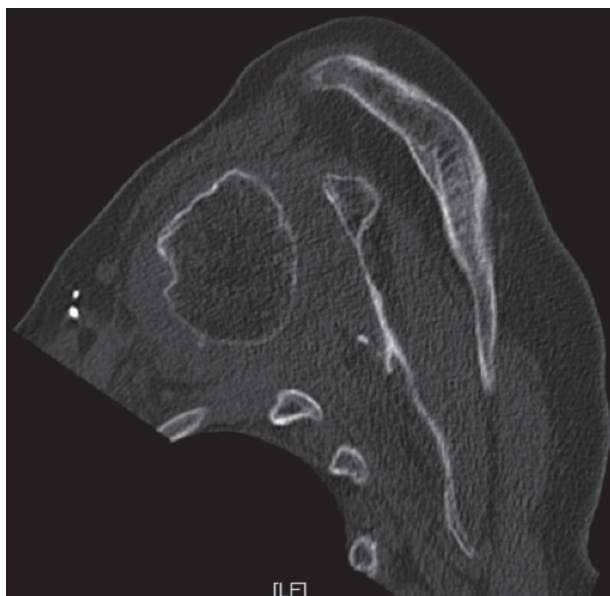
Axial CT image chronic dislocation and large glenoid bone defect.
